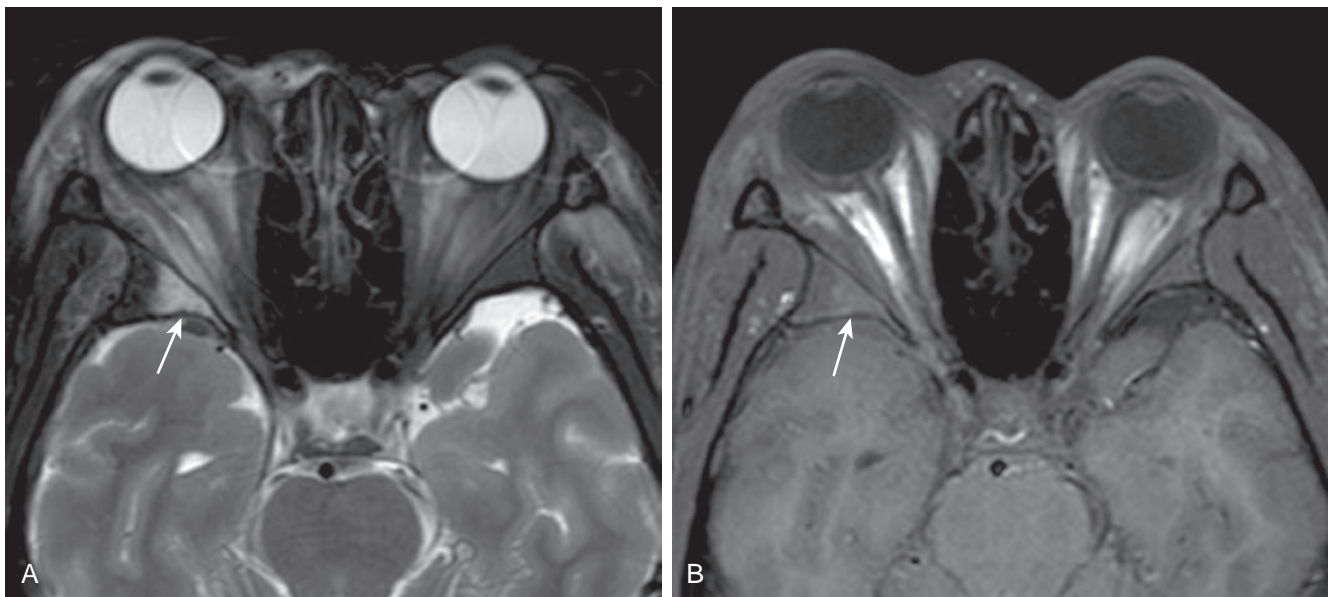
Sickle cell disease. (A) Axial T2-weighted fat-saturated MR image of the orbits demonstrating bone marrow infarction in a patient with sickle cell disease, with T2 hyperintensity of the bone marrow of the lateral wall of the right orbit and adjacent inflammatory changes of the extraconal fat (arrow). (B) Axial T1-weighted fat-saturated noncontrast MR image of the orbit in the same patient demonstrating subtle T1 hyperintensity of the bone marrow from sequestration of red blood cells (arrow).
